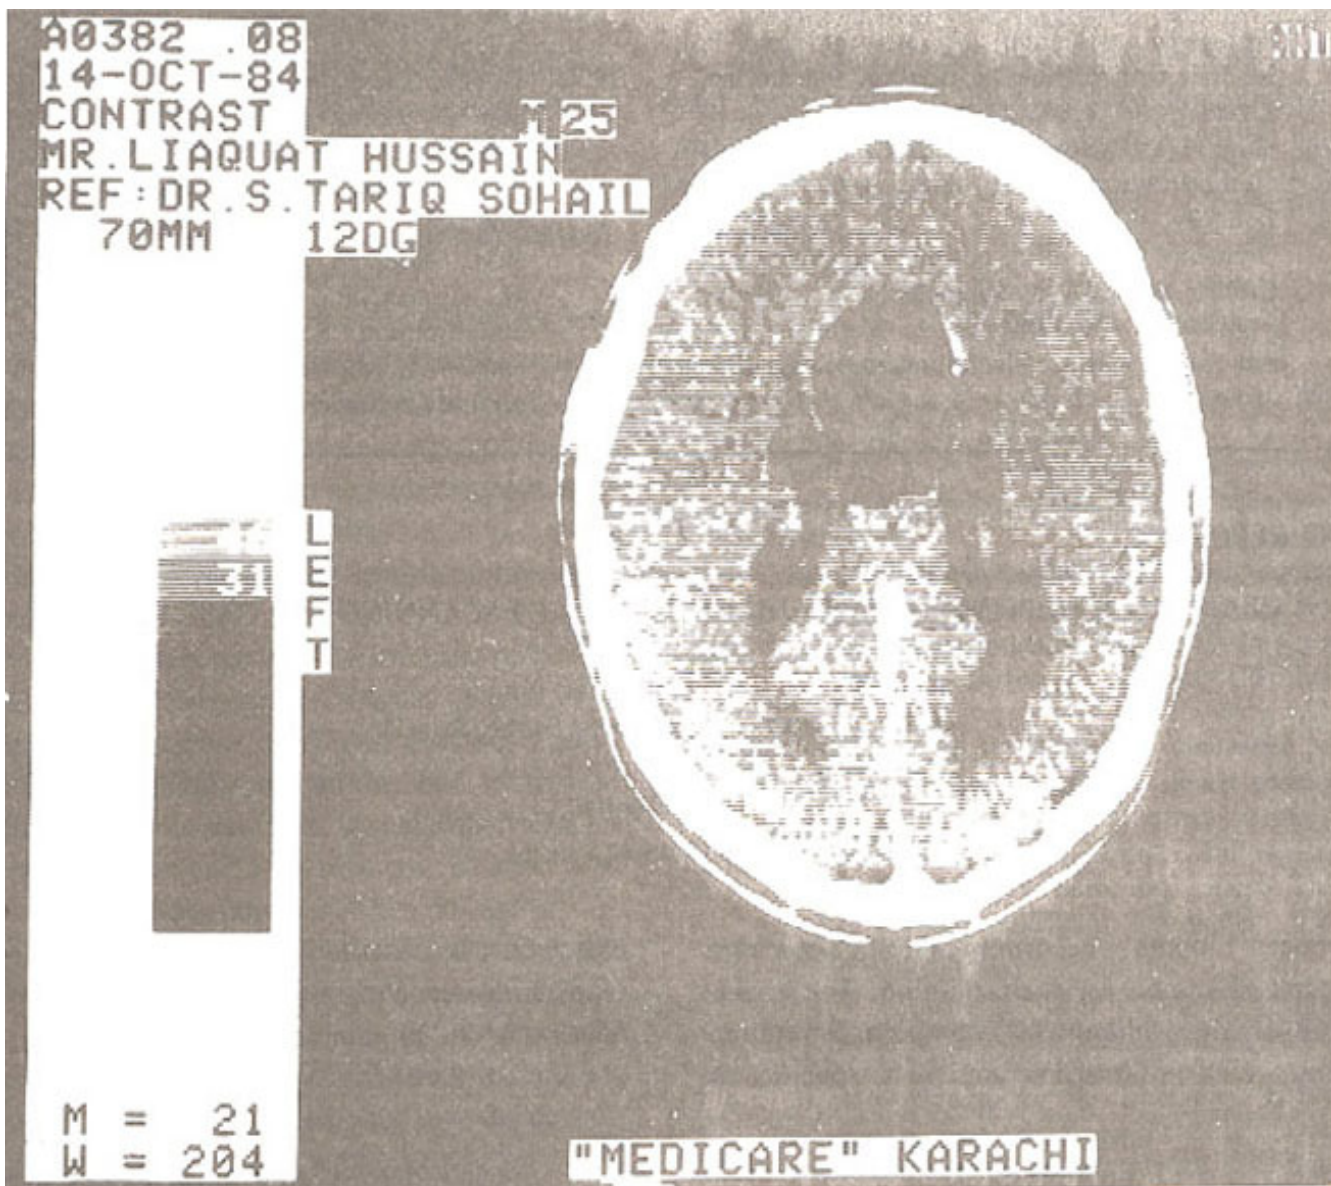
CT Scan showing Lipoma of Corpus Callosum.
